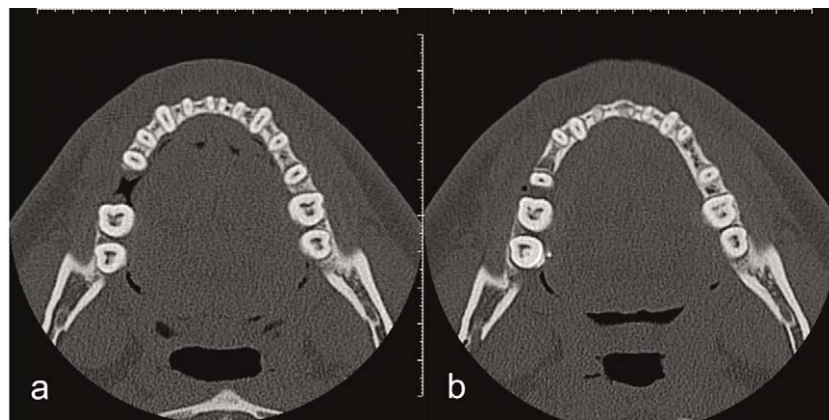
Axial CT slides of mandible at same level. a, Before orthodontic treatment; b, after orthodontic treatment. Note root resorption at apices of front teeth.
